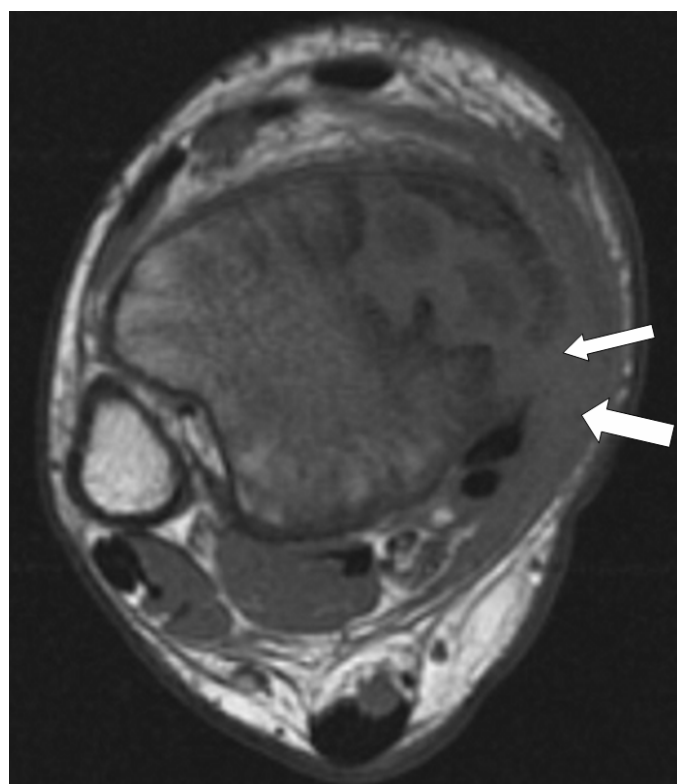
Figure 2A and 2B: Axial T1-weighted MR images of right leg. In figure 2B note extension of inflammatory process (narrow arrow) through cortex to involve adjacent soft tissues (wide arrow).
